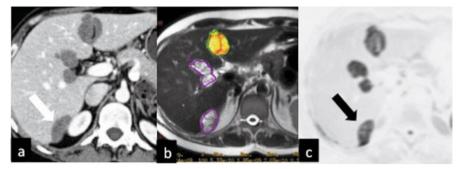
Peritoneal cystic implants (*arrows*) above the liver surface (at the hilum, near the falciform ligament, and within Morison's pouch) on (a) axial computed tomography (CT), (b) axial magnetic resonance imaging (MRI), and (c) on positron emission tomography (PET/CT) in a patient with metastatic ovarian cancer. PET/CT shows the highest contrast resolution
